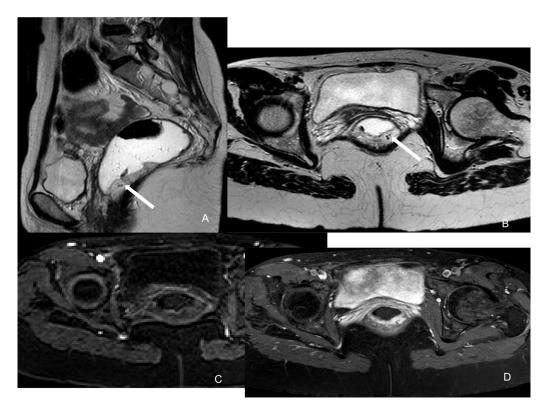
MRI Sagittal T2 (A), Axial T2 (B), injected axial T1 in arterial (C) and tardive (D) phases showed a mass of posterior rectal wall with regular contours, with high-signal in T2, containing phleboliths (arrows), with progressive enhancement and perirectal vascular turgitidy.
